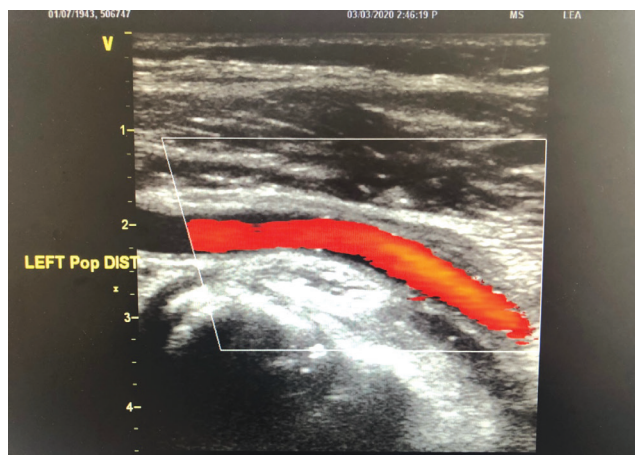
Doppler duplex of the left lower extremity 9 months after popliteal artery PTA demonstrates normal flow in the mid and distal popliteal artery with preservation of the lumen.
